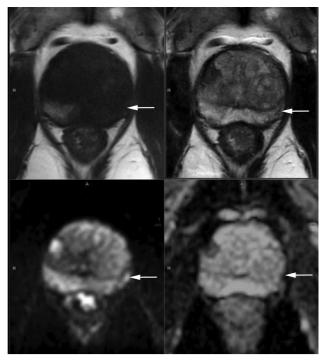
Only an ill-defined T1 and T2 hypointensity in the left lateral peripheral zone. However, focal markedly hyperintense on high b-value DWI and hypointense area on ADC in left lateral peripheral zone measuring less than 1.5 cm (arrow)-PIRAD 4.
